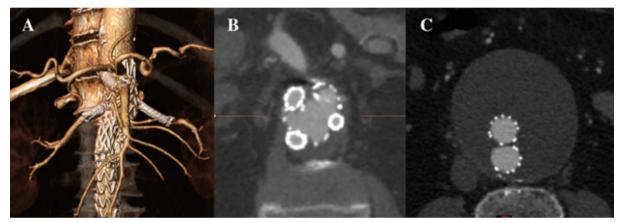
Post-operative CTA: The patient presented in Image 1 was treated with a triple chimney. All grafts are patent (Panel A & B). The post-operative CTA revealed no endoleak (Panel C).
